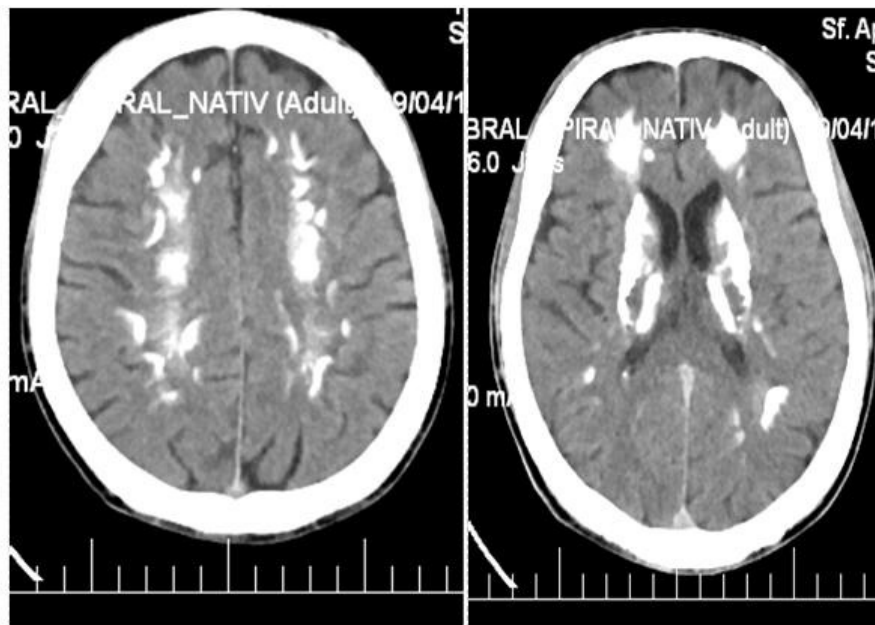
Brain CT- multiple bilateral intracerebral, macro- and micronodular calcification.
